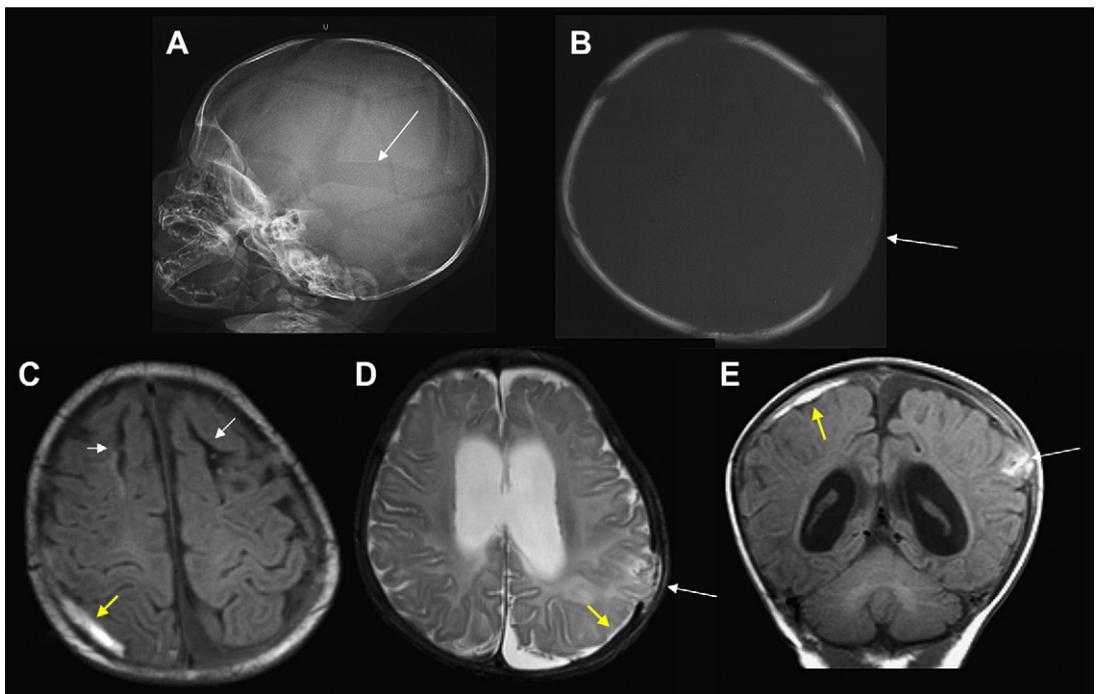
Nine-week-old infant with triad and alleged NAI; also, history of traumatic labor and delivery. Skull film (A), CT (B) plus FLAIR (C), T2 (D), and T1 (E) MR imaging shows bilateral skull fractures with left growing fracture (long white arrows), chronic bifrontal cerebral white matter clefts (short white arrows) (C) plus acute, subacute, and chronic SDHs/rehemorrhages (yellow arrows).
